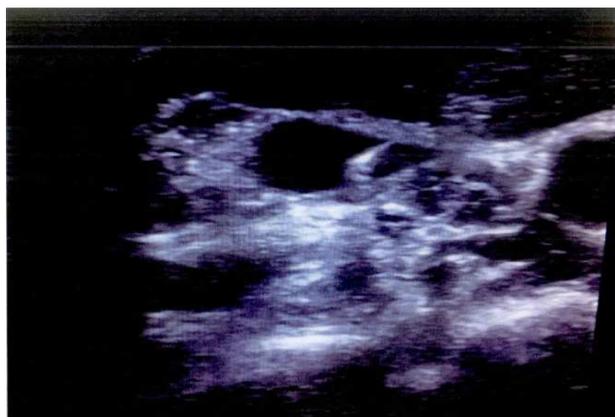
Ultrasound guided internal jugular vein catheterization retrograde catheterization pressure
